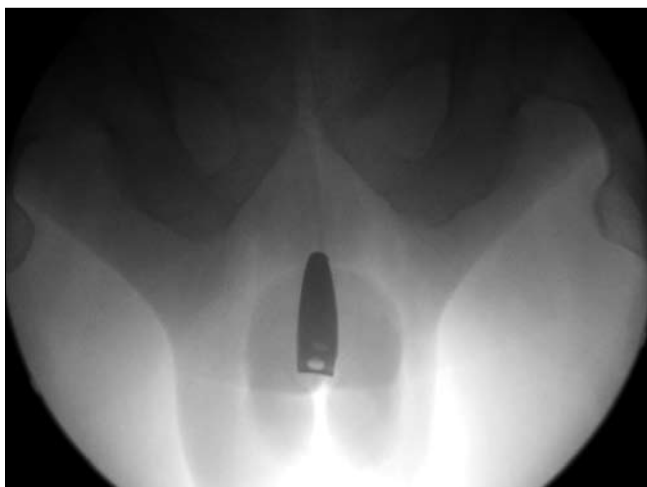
X-ray showing urethral foreign body (nail clippers).
